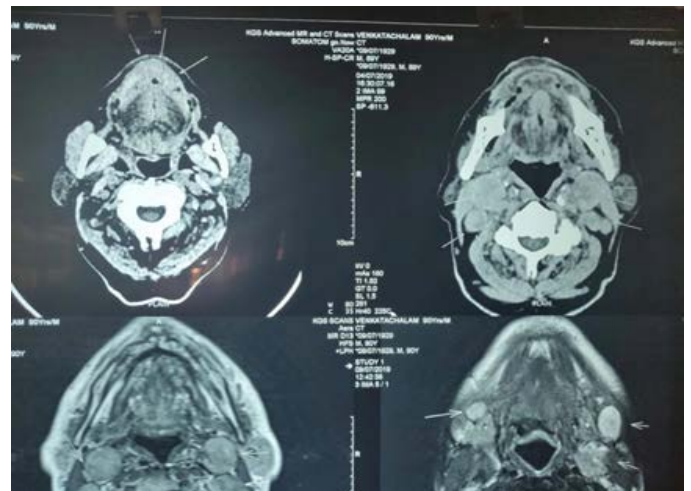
Magnetic Resonance Imaging showed mixed signal lesion and Computed tomography showed mixed
